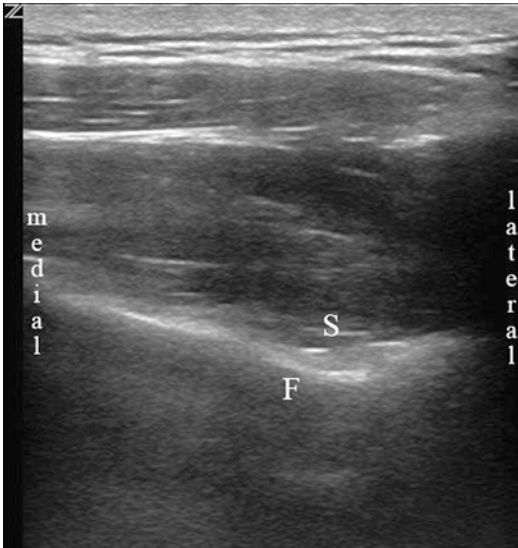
Ultrasonographic appearance of the supra-shoulder fossa (*F* fossa, *S* supraspinatus muscular fascia)
